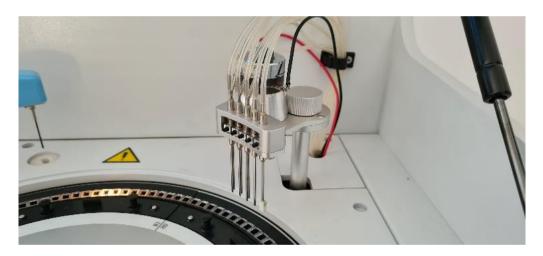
The automatic ultrasonic cuvette cleaning system.
